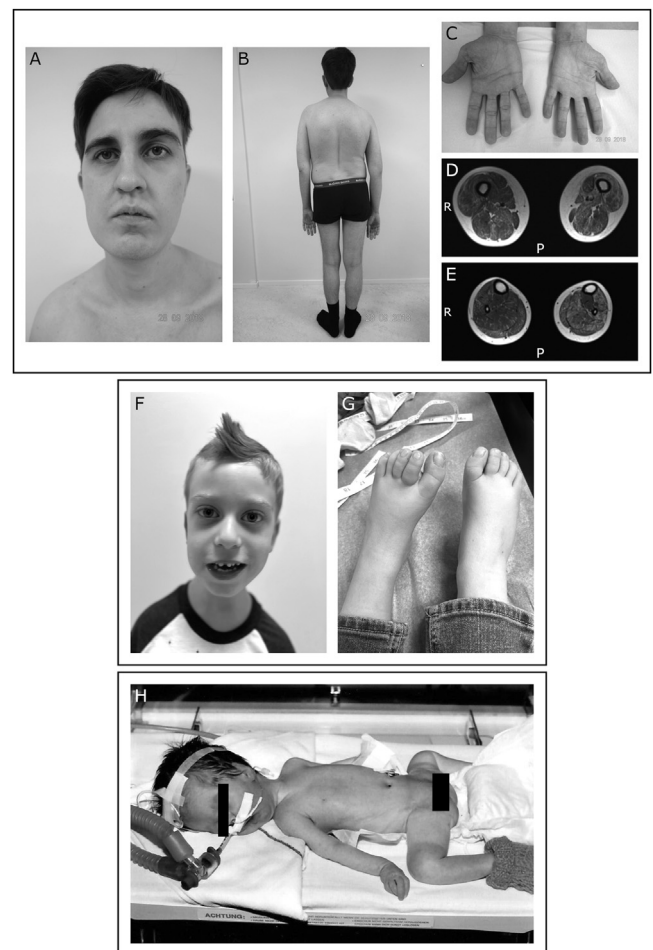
The asymmetric facial expression of Patient 1 (A). His left lower limb is shorter and thinner than his right (B). The hands showed a 1.5 cm difference in breadth (C). In MRI, smaller muscle bulk was seen on the left side both at thigh (D) and lower leg (E) level. Patient 2 had elongated, myopathic facies and slight asymmetry of the facial expressions (F). The right leg was 3 cm shorter than the left one (G). Patient 4 had a very severe clinical picture at birth with extreme hypotonia, areflexia, no spontaneous movements, no independent respiratory effort, persistent bradycardia and arthrogryposis affecting all large joints (H).
